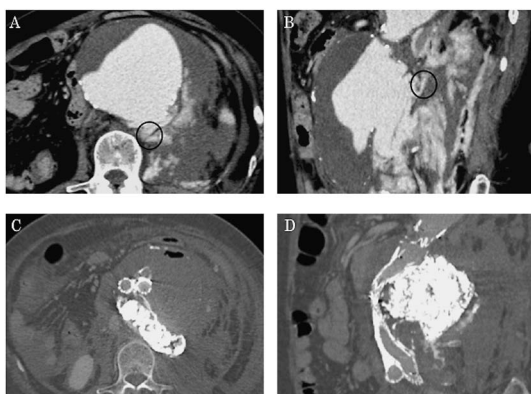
Sac embolization in EVAR for ruptured AAA. Preoperative contrast-enhanced CT scan (A: axial image, B: sagittal image) showed 9.0-cm ruptured AAA and extravasation of the contrast material. Black circle indicates the bleeding site. Postoperative bone window CT image (C: axial image, D: sagittal image) showed the accumulation of NBCA from sac to retroperitoneal space, it covered the bleeding site.
